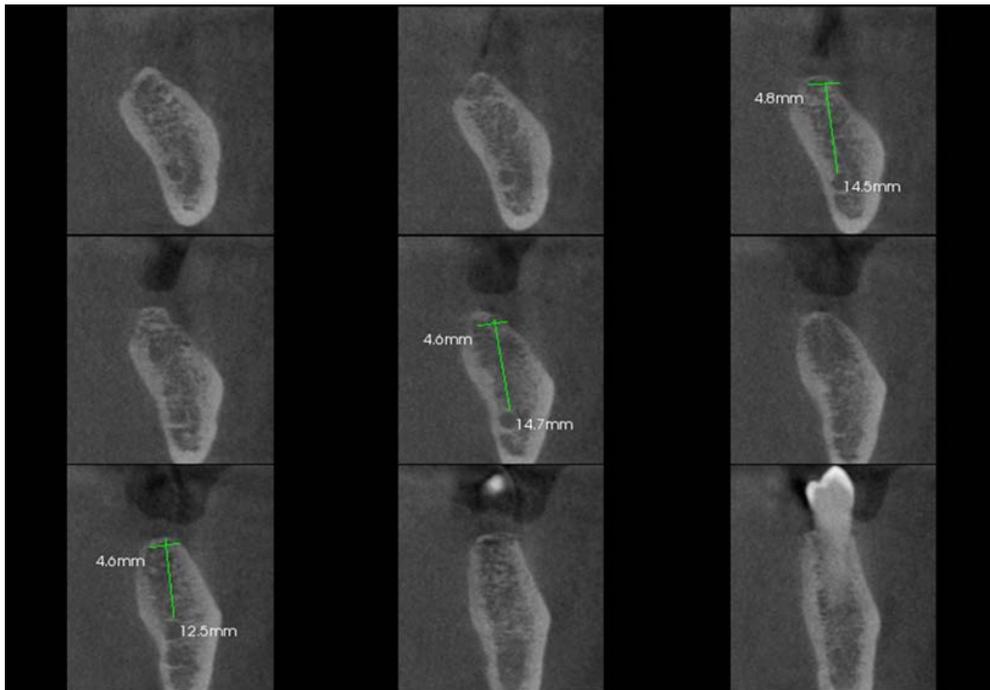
Volumetric 3D CT-CBCT
